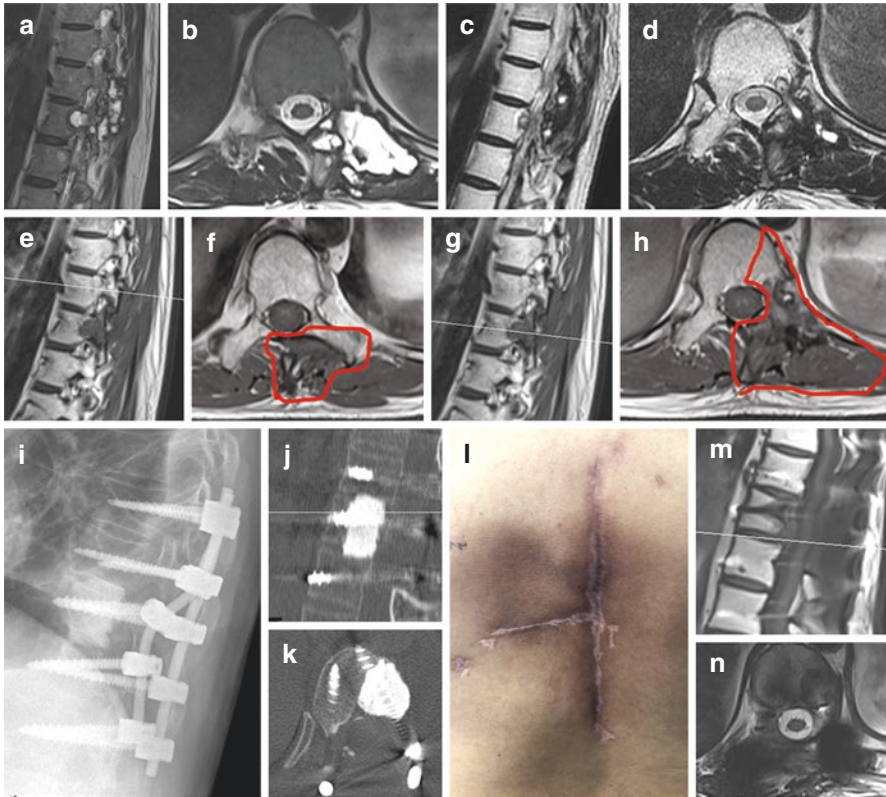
Thoracic ES surgically treated with en bloc resection, stabilization, and reconstruction. The 48-year-old male patient was operated 3 years ago because of a left humerus ES. Follow-up imaging showed a thoracic tumor, affecting the Th9–11 level causing mild pain without neurological deficit nor spinal instability (a, b). Neoadjuvant chemotherapy and irradiation resulted in the shrinking of the tumor mass (c, d). Planning of the Enneking’s appropriate en bloc resection (e–h) and stabilization. Postoperative X-ray after the surgery (i). A PMMA bone cement spacer anchored to the posterior rod was used to reconstruct the anterior column (j, k). A “sliding” latissimus flap was used for soft tissue reconstruction that resulted in perfect wound healing (l). The surgery and adjuvant radiation therapy provided local control (m, n—1-y follow-up)
